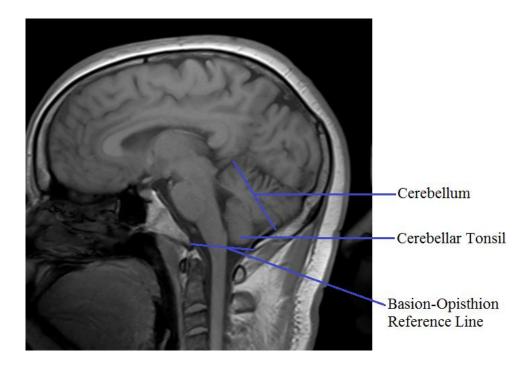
MRI sagittal section through the brain showing the cerebellar tonsil taken at Cancer Diseases Hospital, Radiology Department.
